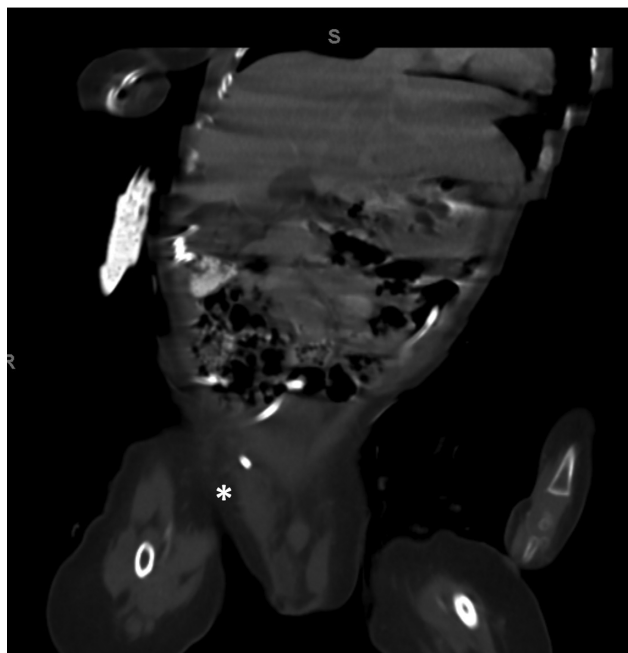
Coronally oriented CT demonstrating malpositioned tip of the distal shunt within the right inguinal canal with a patent processus vaginalis and CSF within the right scrotal sac (white asterisk).
